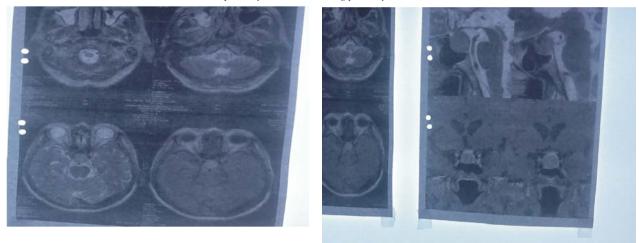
MRI BRAIN OF THE PATIENT:
